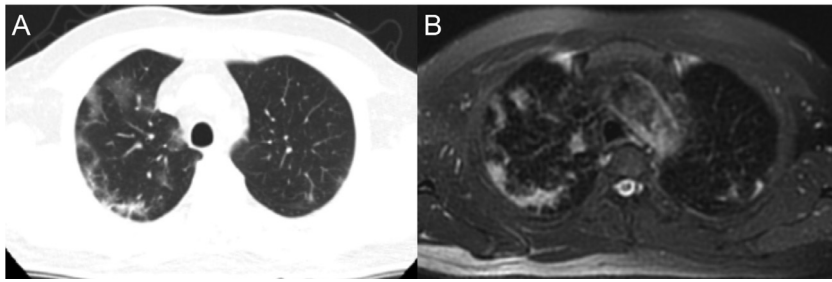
Images of a 50-year-old male, showing ground-glass areas with bilateral peripheral distribution similarly visualized on both computed tomography (a) and magnetic resonance imaging (b).
